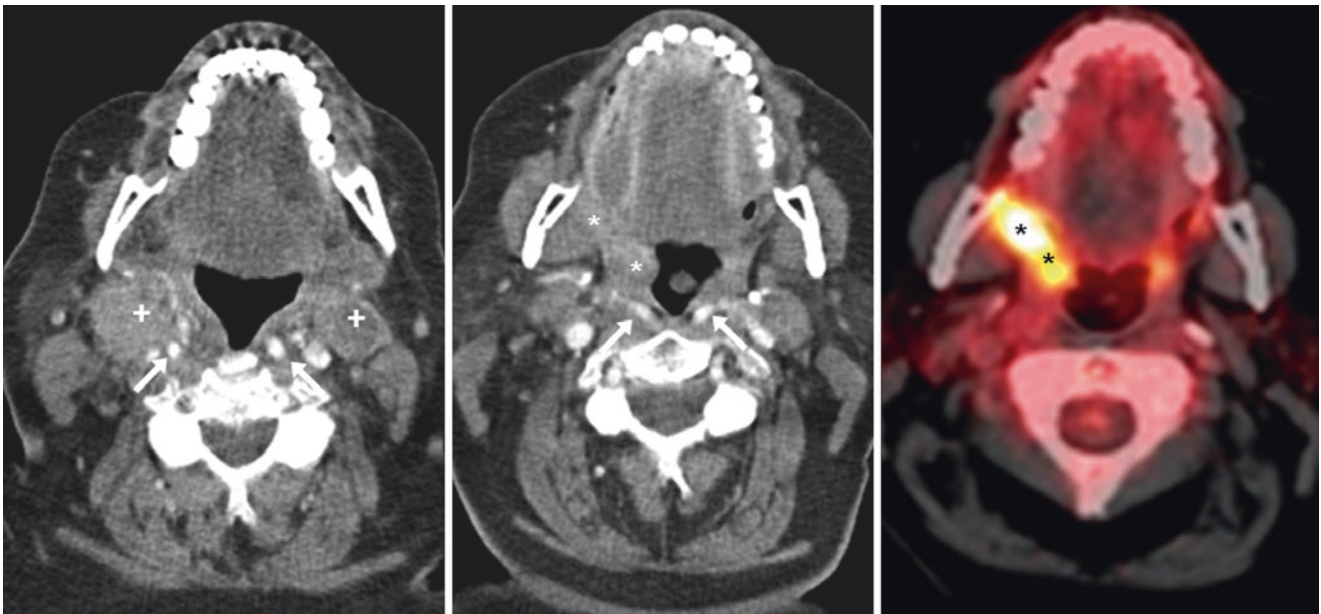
Comparison case of palatine mass and retropharyngeal ICA. A 67-year-old had bilateral level 2A metastatic lymph nodes (*plus signs*) on contrast-enhanced CT (*left*), and a right retromolar trigone lesion (*asterisks*) extending into the palatine tonsil (*middle*). The SUV was greater than 6.0 on fused ^{18}F FDG PET-CT (*right*). Bilateral retropharyngeal ICAs (*arrows*) were present, with the right ICA just posterior to both the right level-2A lymph nodes and the palatine tonsil mass
